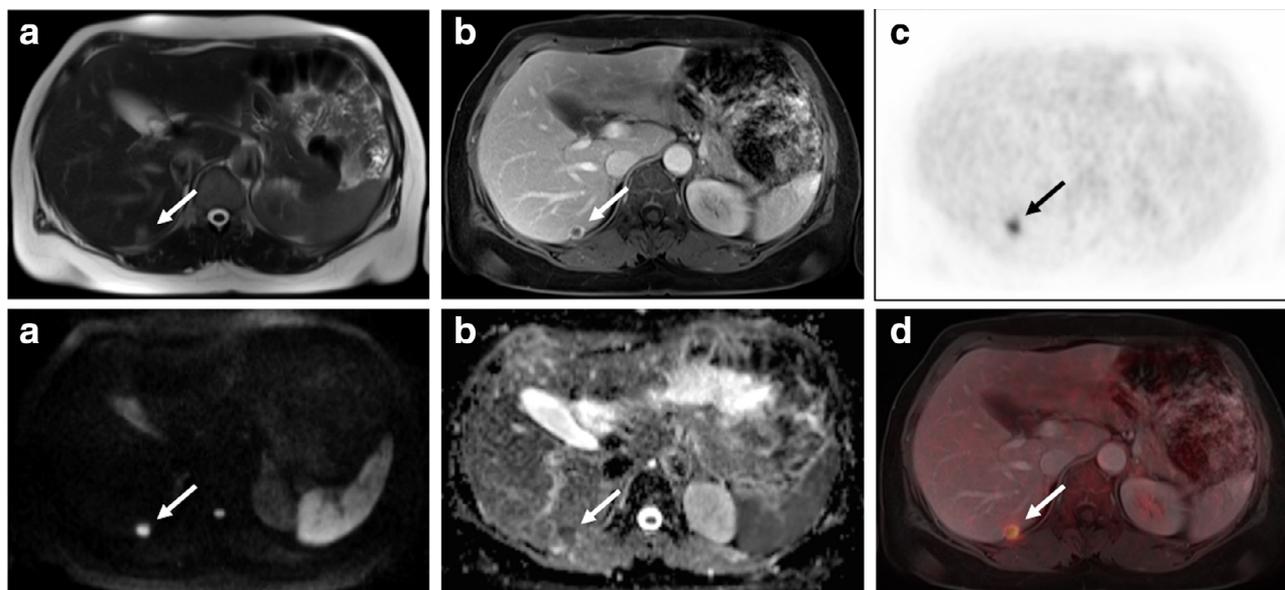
Restaging examination of a 62-year-old patient with a liver metastasis of an ovarian cancer. T2-weighted images (a) show a hyperintense subcapsular liver lesion with rim enhancement (b, contrast-enhanced T1w), which reveals restricted diffusivity (d, DWI; e, ADC-map) as well as a pathologically increased glucose metabolism of 18F-FDG PET (c,f).
